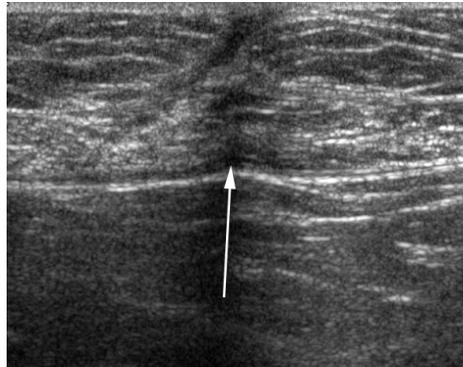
Postoperative transverse sonogram 2 years following the three-layered direct suture repair of an incisional hernia. The rectus muscles are attached to each other, and the linea alba has disappeared. Scar tissue (arrow) separates the rectus muscles. The posterior fasciae of both rectus muscles are continuous.
